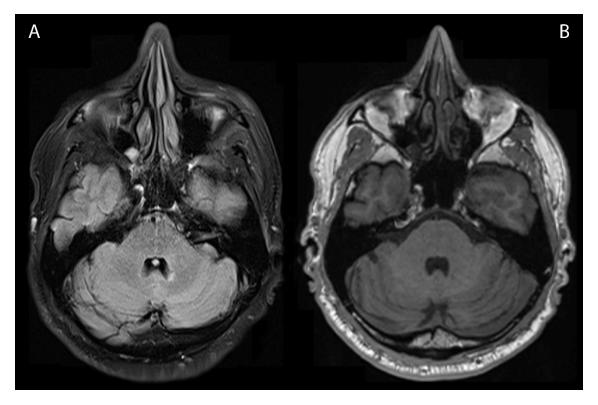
Post-treatment Case 1. Axial T2-weighted FLAIR brain MRI scan obtained 1 month after steroid treatment onset. A. MRI examination shows a significant reduction in number and size of hyperintense lesions in the infratentorial region. B. With a complete regression of enhancing lesions in cerebellar hemispheres and peduncules.
